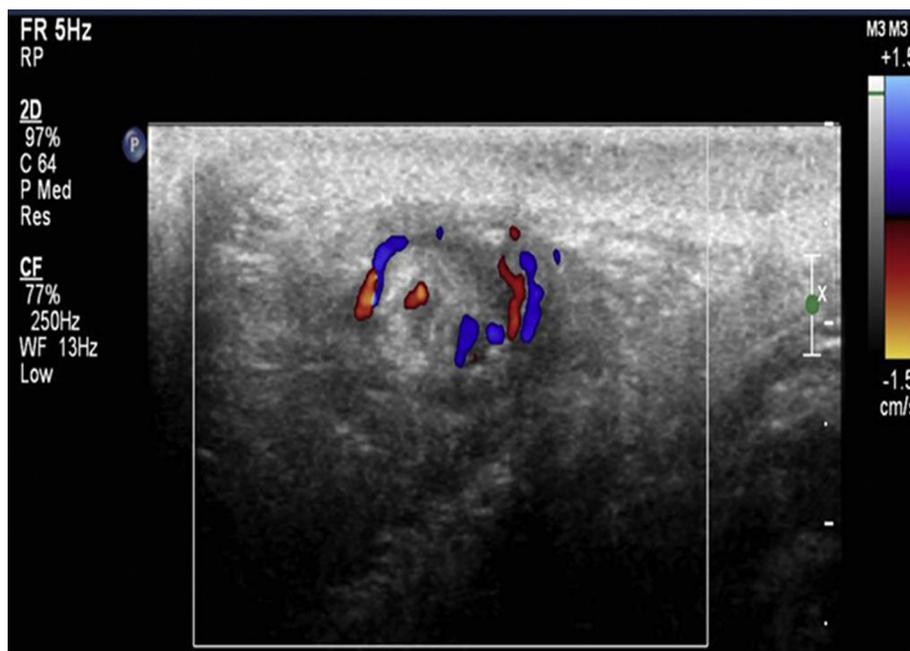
Whirlpool sign seen by Doppler ultrasound indicating the presence of the supercoiled spermatic cord involved in testicular torsion. (Photo from S. Boopathy Vijayaraghavan, MD).
